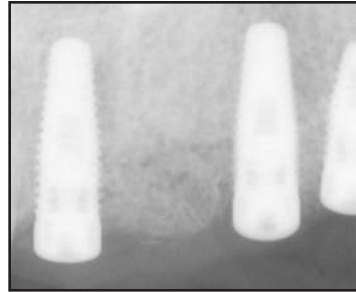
Radiograph of implants in place.
